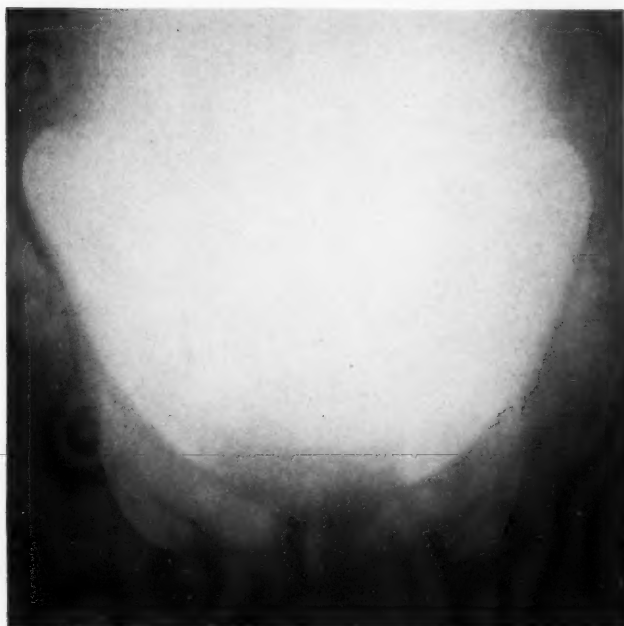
Radiograph of bladder filled with normal salt solution.
